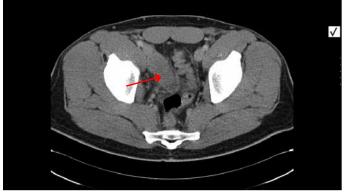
A computed tomography scan demonstrating soft tissue mass in the right sided pelvic mass compressing the ureter.
